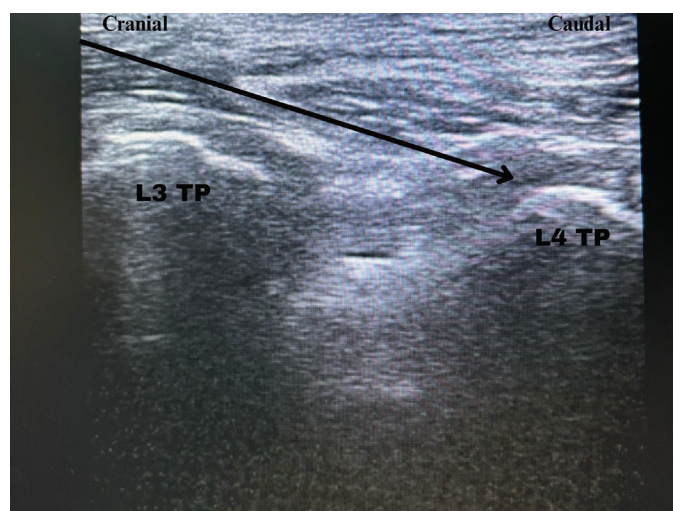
Ultrasound image of lumbar erector spinae plane block
